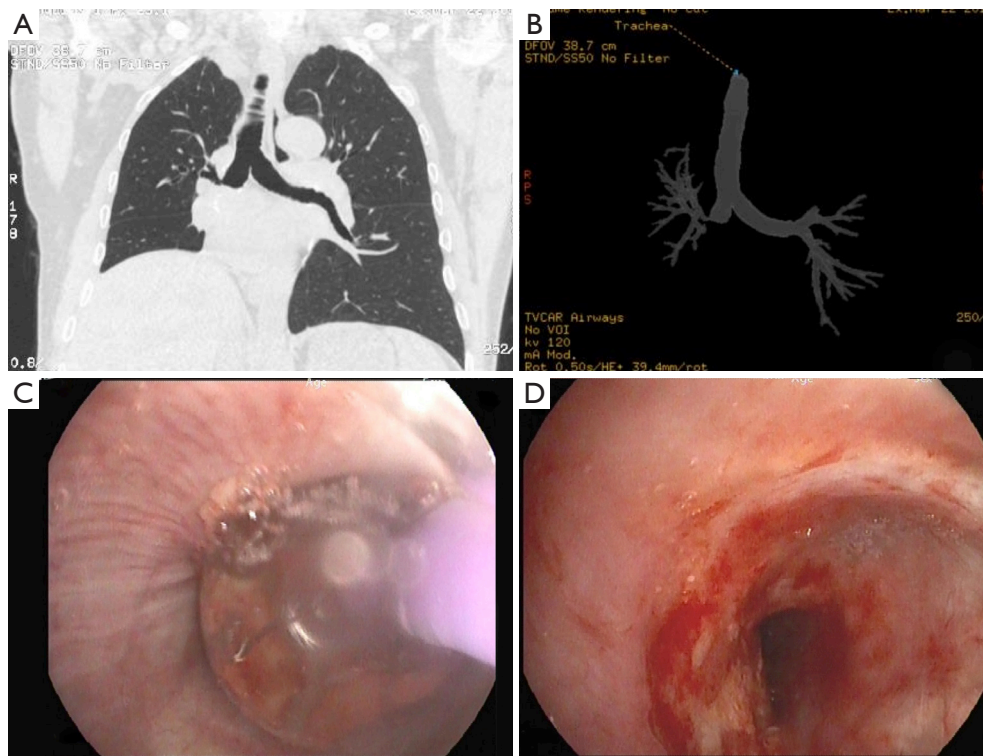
Stenosis of bronchus intermedius. (A) Coronal view of chest CT scan showing almost complete obliteration of bronchial lumen distal to anastomosis; (B) helical chest CT with 3D images of the airway showing the stenosis at the bronchus intermedius; (C) repeated balloon dilation; (D) final result. CT, computed tomography.
